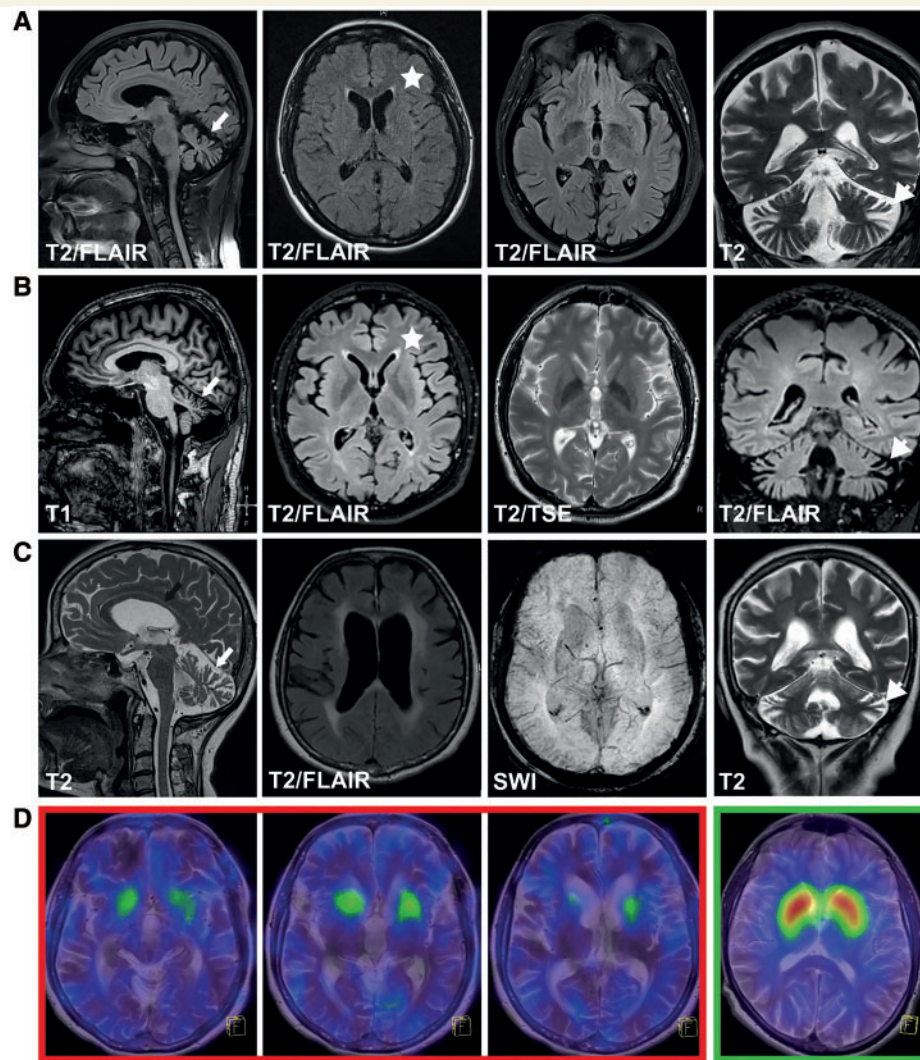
Cranial imaging in ATP13A2 HSP cases. Routine MRI in Patients HIH22132.II.1 (A) (disease duration 7 years), HSP84.II.3 (B) (disease duration 7 years), and HIH21480.II.3 (C) (disease duration 11 years). Images demonstrate vermian (white arrow) as well as hemispheric cerebellar atrophy (white arrowheads) that was progressive over time in Patient HIH22132.II.1 (not shown). Generalized cortical atrophy was present in all cases. In Patients HIH22132.II.1 (A) and HSP84.II.3 (B) an 'ear of the lynx' sign (T₂ hyperintensity of the anterior fornix of the corpus callosum, marked by an asterisk) was present, while periventricular white matter changes were more pronounced in Patient HIH21480.II.3 (C). The latter case also demonstrated thinning of the corpus callosum (C, marked by black arrow). (D) Transversal fused ¹²³I-FP-CIT SPECT and T₂-weighted MRI images of three representative sections of the striatum in Patient HIH21480.II.3 (red box) and a representative section of the striatum from a healthy adult (green box, far right). Patient HIH21480.II.3 demonstrates severely reduced striatal dopamine.
